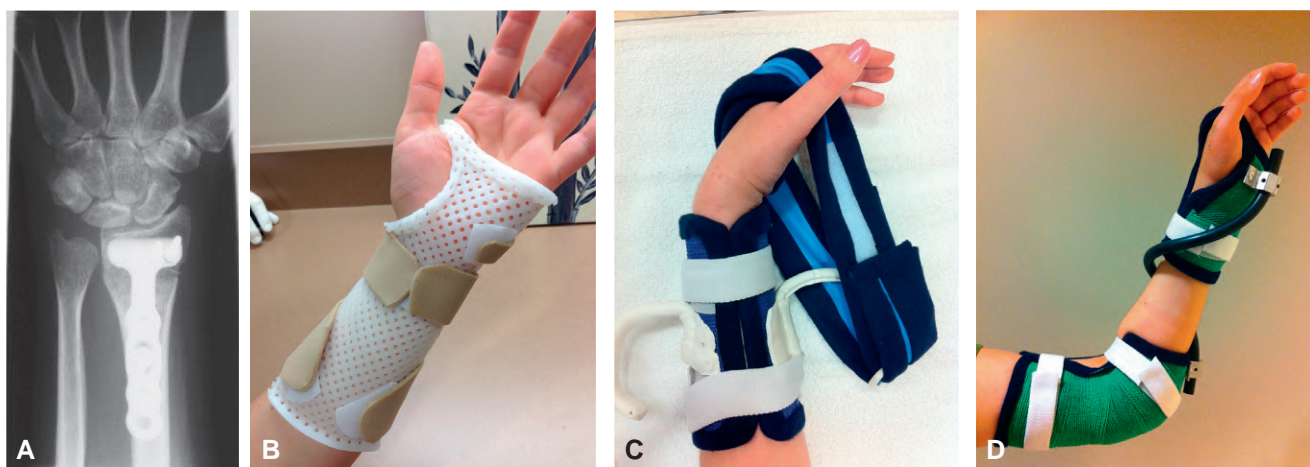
(A) A radiograph of open reduction and internal fixation of a comminuted wrist fracture. (B) A forearm-based wrist immobilization orthosis used during the initial stages of healing. When adequate healing has occurred, a wrist flexion mobilization orthosis (C) and a forearm supination mobilization orthosis (D) are fabricated to help increase functional range of motion.
